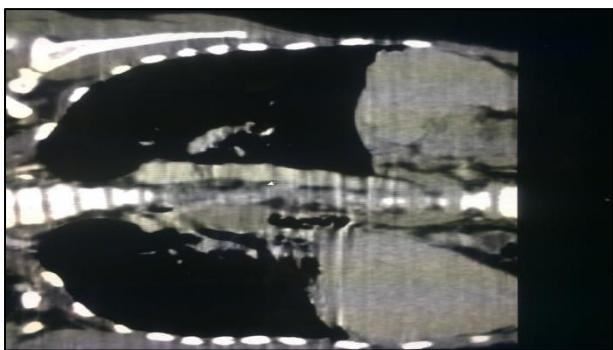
(C): CT thorax of resolution of right middle lobe consolidation with treatment.
